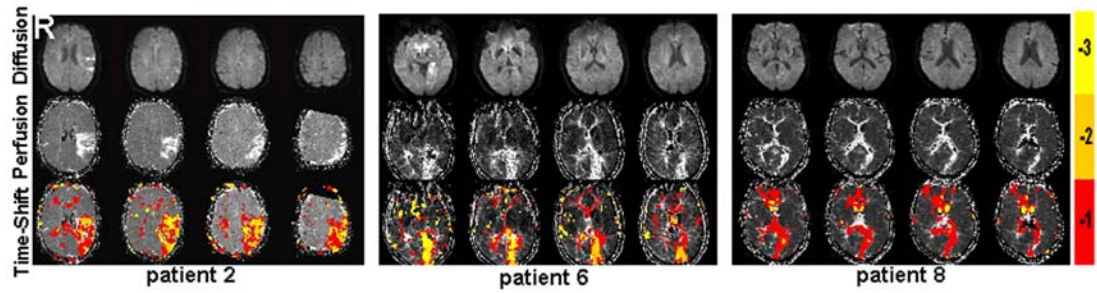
Detailed time-shift analysis (TSA) results of 3 stroke patients (2, 6, 8) with a time-shift range from -3 TR to +3 TR. In these 3 patients who have large mismatch areas, the areas which showed time delays to global mean corresponded to the areas of hypoperfusion as identified by MTT maps and not to the infarct cores which are reflected in DWI. -1, -2, -3 in color bar indicates -1 TR, -2 TR, -3 TR time shift.
